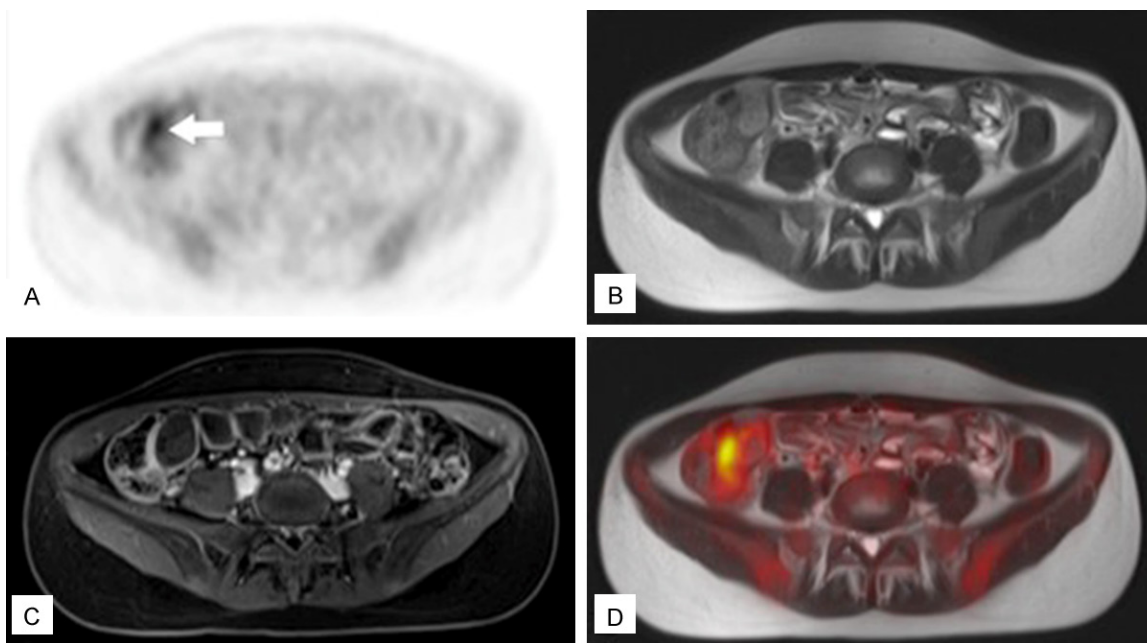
False positive PET case. Axial PET (A), axial T2-weighted HASTE (B), axial CE-VIBE (C), and fused PET/MR (D). A focal area of marked FDG uptake was identified in the distal ileum/ileocecal valve (arrow). However, no bowel wall thickening or hyperenhancement was seen in this region on MR. Additionally, no active bowel inflammation was observed in this region during surgery.
